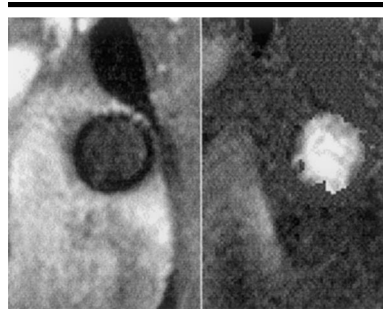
Velocity-encoding cine MR images (15/3.8) of pulmonary artery. (Left) magnitude and (right) phase images were acquired orthogonal to nitinol stent in main pulmonary artery position. Presence of low-signal-intensity ring around pulmonary artery on magnitude image represents susceptibility artifacts derived from stent. High signal intensity within stent lumen on phase image is indicative of forward flow in pulmonary artery during systole.
